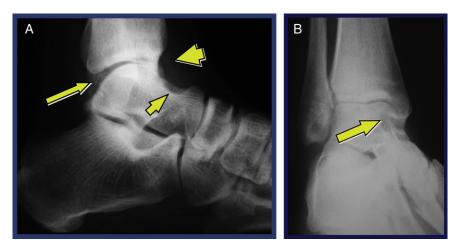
(*A*) The lateral radiograph was overtly impressive and revealed only mild anterior joint space narrowing with a trace osteophytic lipping. Findings typical for chronic ankle pain. The only unusual characteristics noted in retrospect were a scalloped margin at the dorsal neck of the talus (small arrow head), an enlarged posterior hiatus (long arrow) and a spherical scalloped margin in the distal anterior tibial plafond (Large arrow head). (*B*) The ankle mortise was narrowed however was completely congruous in alignment without evidence of osteochondral defect. There was subtle evidence of a large circular lucency in the subchodral aspect of the medial talar shoulder indicated by the arrow.
